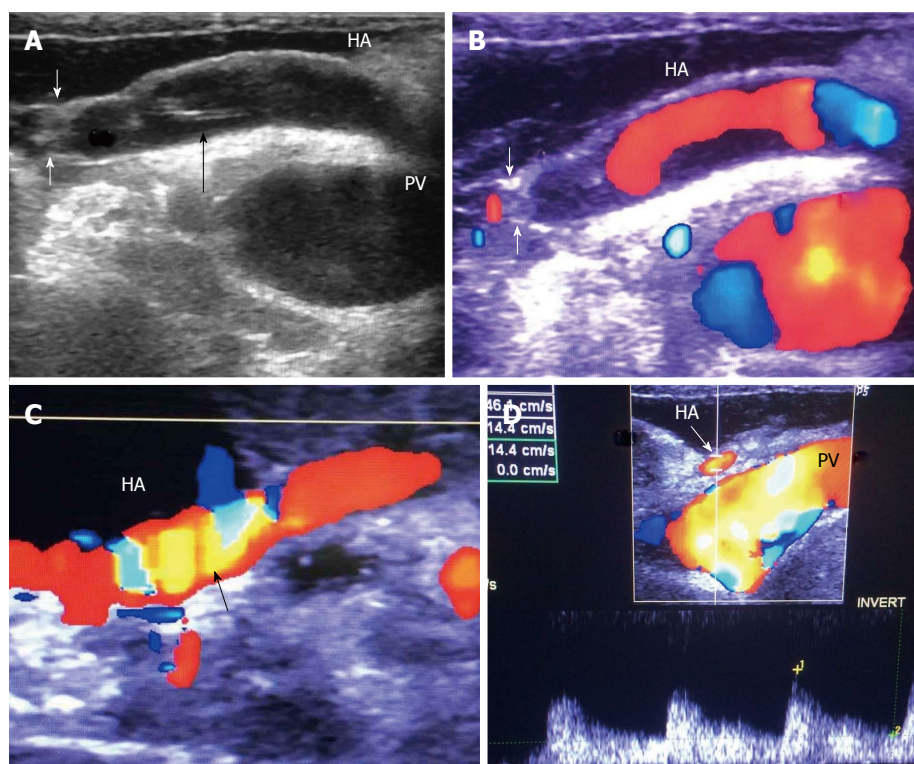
Intra-operative hepatic artery dissection and thrombosis. A: IOUS B-mode image, showing HA anastomotic stricture (White arrows) and a dissecting flap at the recipient side of the artery (black arrow); B: Color image showing abrupt occlusion of the HA proximal to the anastomosis and acute thrombosis at the site of anastomosis; C: Color image after revision of the anastomosis, showing patent artery with color aliasing at the region of the anastomosis (arrow); D: Color Doppler image, showing normal biphasic arterial flow distal to the anastomosis. HA: Hepatic artery; PV: Portal vein.
